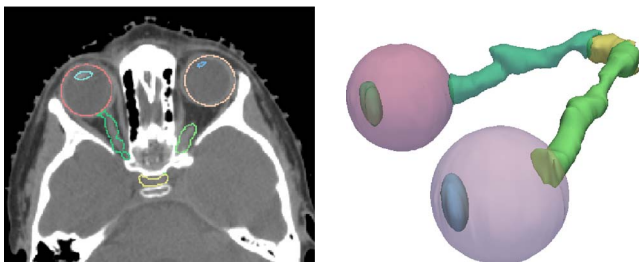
The segmented organs (eyeballs, lenses, optic nerves, and chiasm) on a CT slice and their 3D model.
